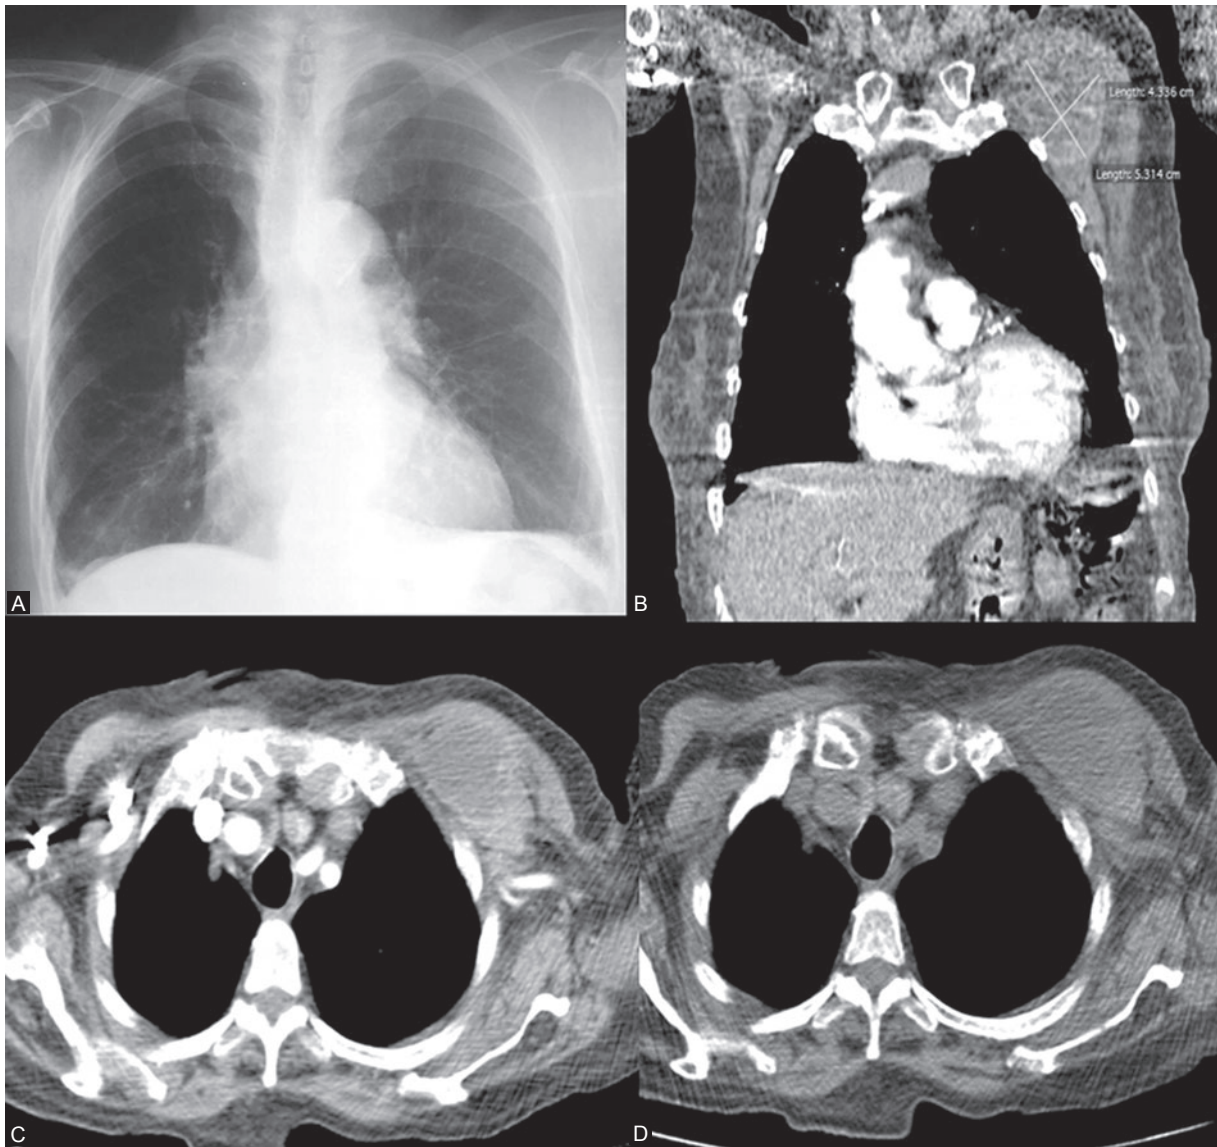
A: Chest X-ray with evident asymmetry between both infraclavicular regions and left clavicle upward shift. Note the increased density of the ipsilateral hemithorax upper portion. B: computerized axial tomography (CAT) coronal reconstruction showing the left infraclavicular region tuberculous abscess. CAT sections at simple (C) and contrasted (D) phases showing a left subpectoral collection with thick capsule that enhances in an annular shape after intravenous administration of non-ionic iodized contrast, of semi-liquid content.
